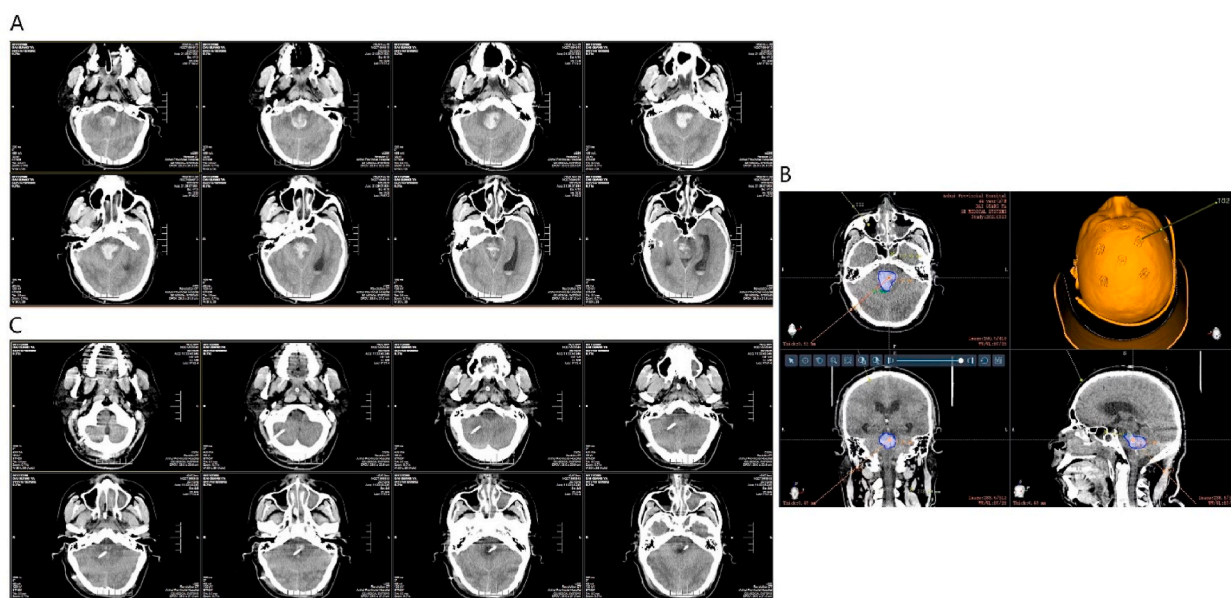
Operative result. (A) Head computed tomography before operation. (B) Operative plan. (C) Head computed tomography after operation.
